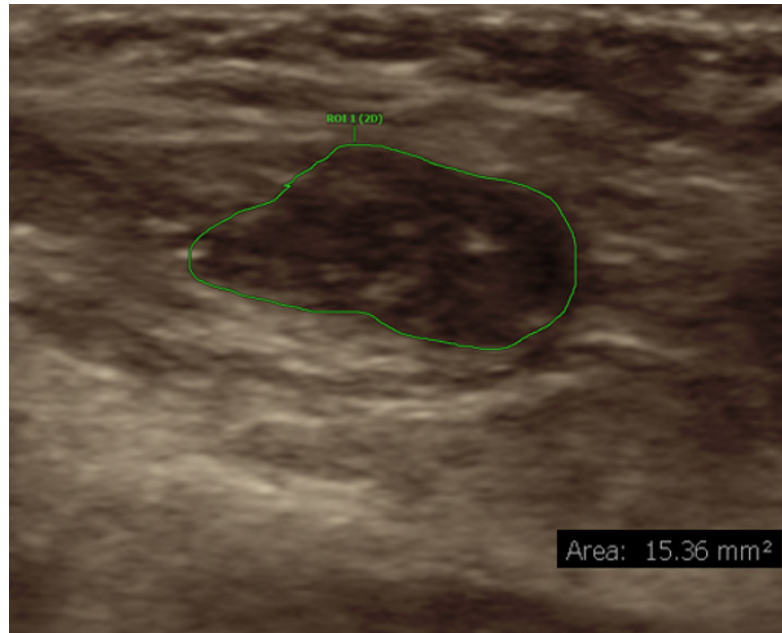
Transverse ultrasound image of a transposed ulnar nerve prior to injection, with cross-sectional area measured at 15 mm². The nerve is enlarged and deformed with complete loss of normal fascicular morphology (grade 3)
